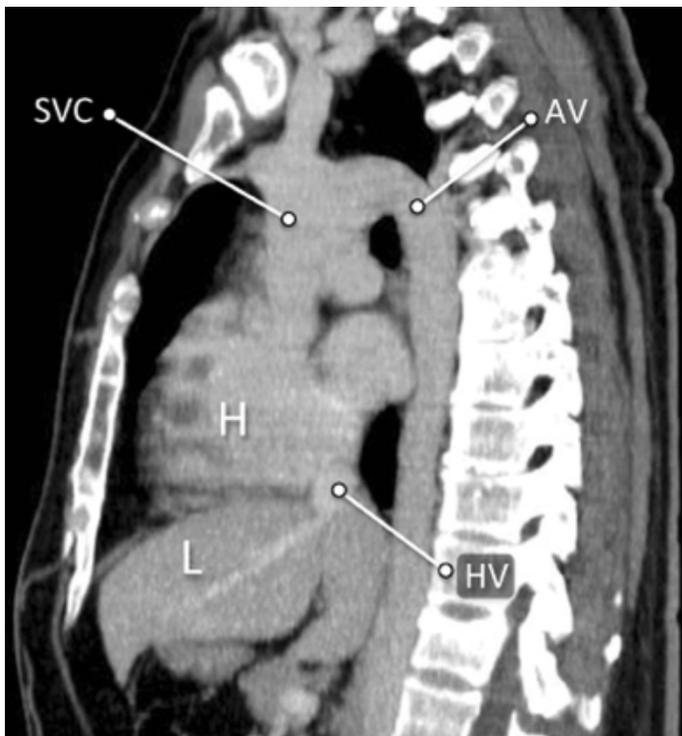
Contrast-enhanced multidetector computed tomography axial (1), coronal (2), and Sagittal (3) multiplanar reconstruction that shows the congenital anomalies azygos continuation of the inferior vena cava, with a dilated azygos vein (AV), normal superior vena cava (SVC), and hepatic vein (HV) of the liver (L) connected directly with the right atrium of the heart (H)
